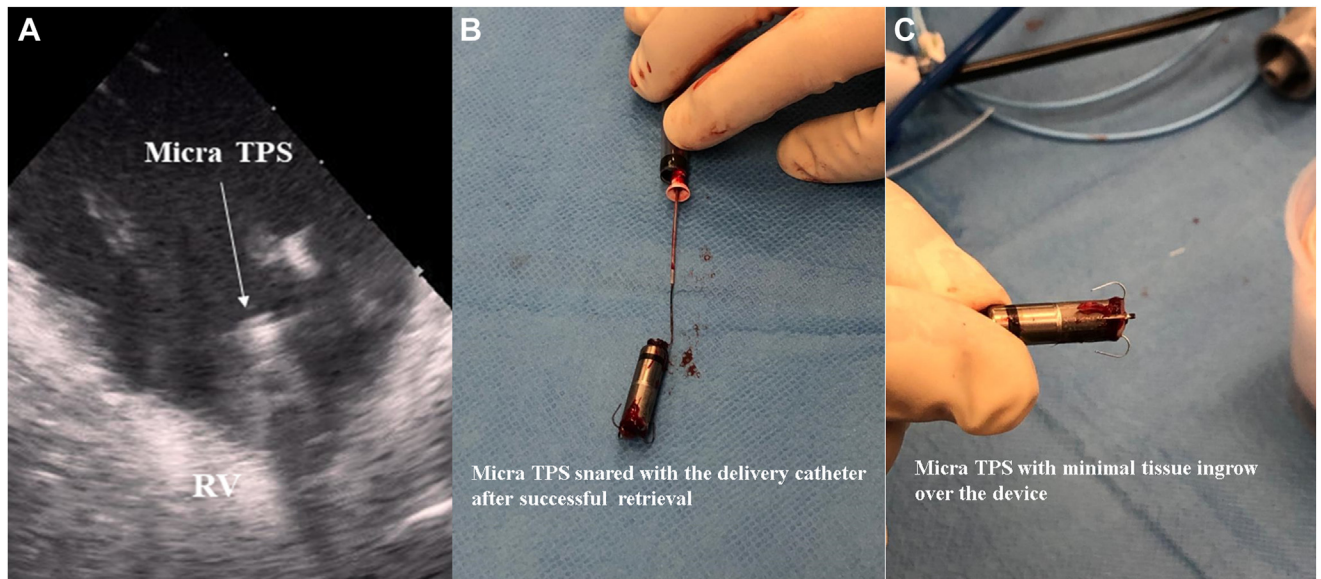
A: Intracardiac echocardiography focused on right ventricle (RV). Arrow indicates no any tissue ingrown on the docking button and proximal part of Micra (Medtronic, Minneapolis, MN) device. B, C: Images of extracted Micra leadless pacemakers demonstrating nice attachment of the single-loop snare over the docking button (B) and minimum amount of fibrosis over the device after 2657 days since implant (C).
